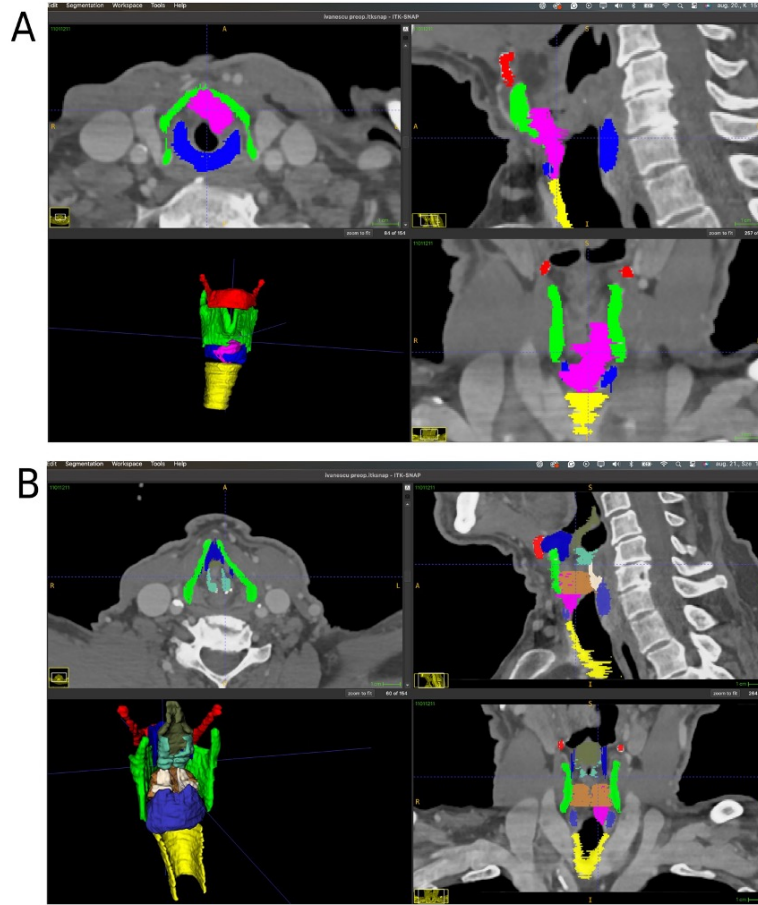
Screenshots of ITK Snap software during the manual segmentation process are shown in *Case 3*. Color legend: red – hyoid bone; green – thyroid cartilage; blue – cricoid cartilage; violet – tumor; light blue – epiglottis; brown – glottis; white – arytenoids; yellow – trachea. A – A generated 3D model (low-left picture) is made by ITK Snap software based on the segmentation. The model is shown from of view with the corresponding CT images B – posterior view (low-left picture) of the model is shown during the segmentation of with the corresponding CT images of *Case 3*.
